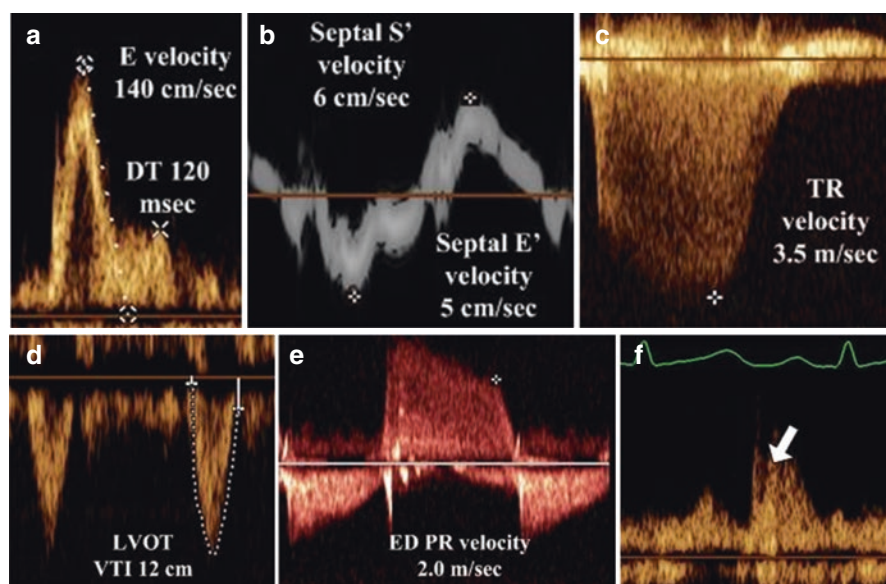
Hemodynamic assessment in patients with shortness of breath and reduced left ventricular ejection fraction. Increased *E* velocity, high *E/A* ratio, and short *E*-wave deceleration time are seen (panel a). These findings coupled with low tissue Doppler *e'* velocity (panel b) and increased *E/e'* ratio suggest increased left ventricular filling pressures. This is further confirmed by high tricuspid regurgitant velocity (panel c), high end-diastolic pulmonary regurgitant velocity (panel e), and D-predominant pulmonary venous flow (panel f). Low left ventricular outflow tract velocity time integral (panel d) and low tissue Doppler S velocity (panel b) are consistent with reduced left ventricular systolic performance
